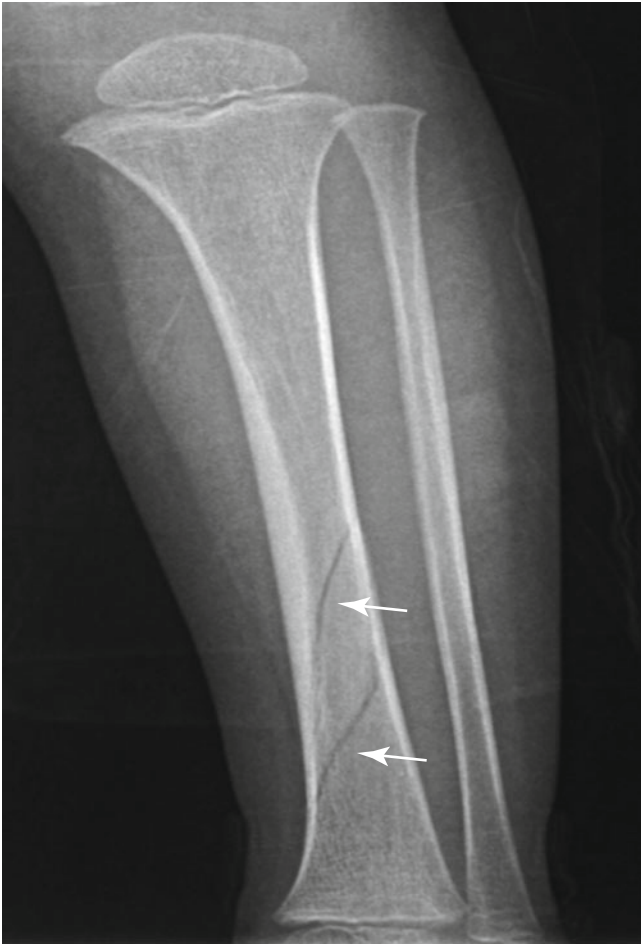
Toddler's fracture in a 3-year-old boy.* Radiograph of the left lower leg shows spiral, nondisplaced fractures (*arrows*) through the distal tibia
